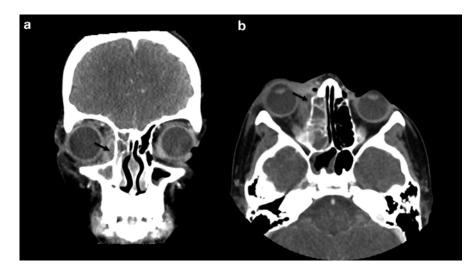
Subperiosteal abscess. Contrast CT scan (a) coronal (b) axial. *Black arrow* shows evidence of peripherally enhancing small subperiosteal abscess collection in the extra-conal space of the right orbit with moderate surrounding edema and mass effect on the adjacent medial rectus muscle. There is fluid opacification in the right ethmoid and maxillary sinuses
